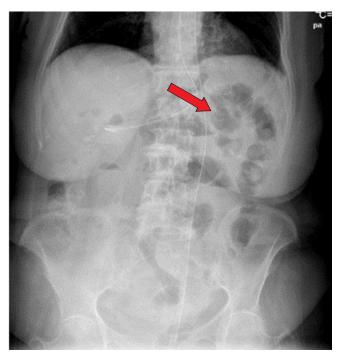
Abdominal x-ray with air-fluid levels.
